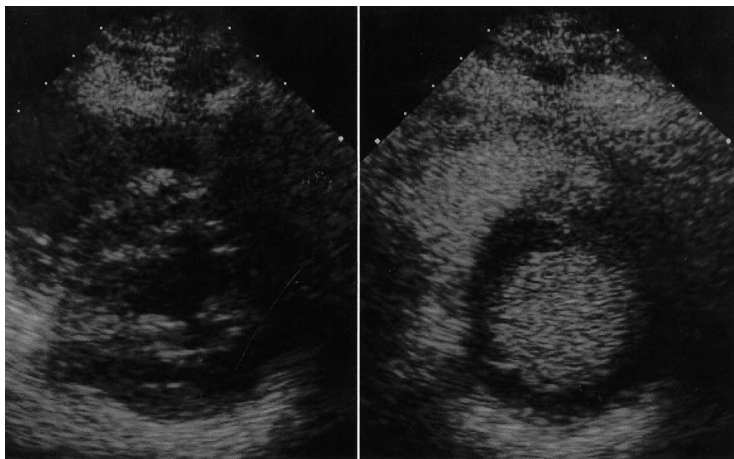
Short axis view of the left ventricle during a stress echocardiogram. The image on the left is taken without contrast and endocardial border detection is difficult. The image on the right is taken after an intravenous bolus injection of 1 ml of contrast (Optison®, Mallinckrodt, UK). The contrast material fills the left ventricular cavity and enhances endocardial border contrast.
